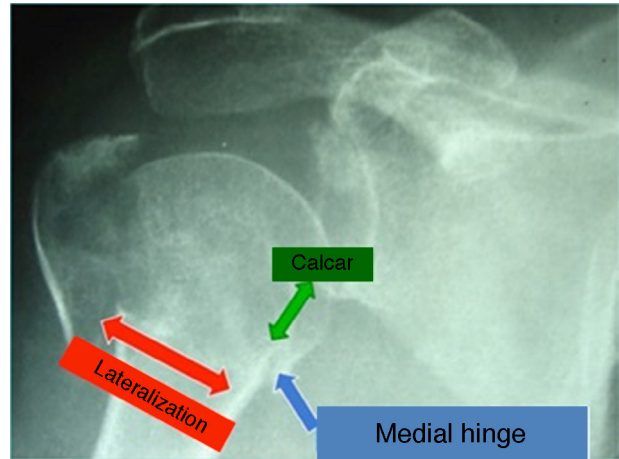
Anteroposterior radiograph of the right shoulder showing valgus impacted fracture of the proximal humerus.
